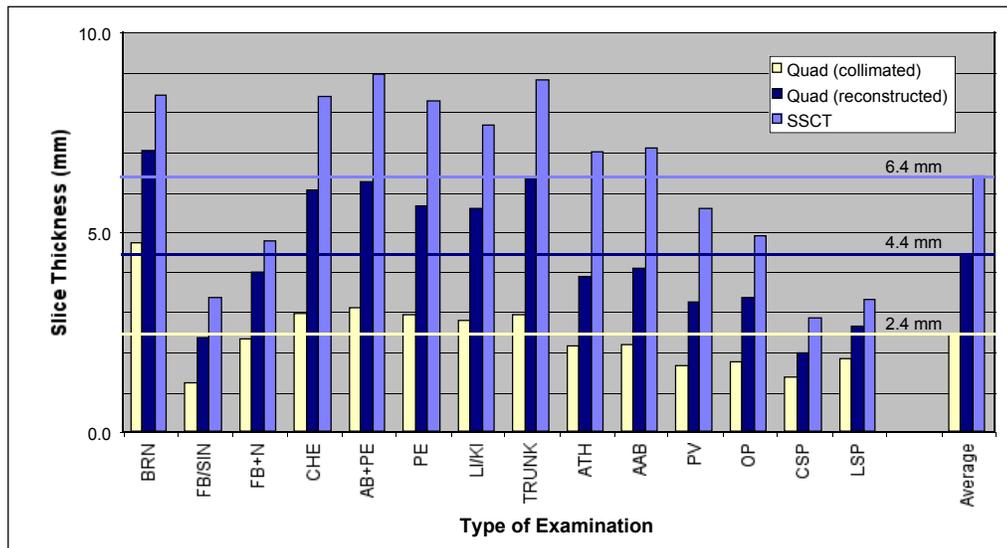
Collimated and reconstructed slice thickness for SSCT and quad slice MSCT scanners. Both collimated and reconstructed slice thickness used with quad scanners (2.4 and 4.4 mm, respectively) is much lower compared to SSCT practice (6.4 mm, collimated = reconstructed) on average (types of examination: BRN = routine brain, FB/SIN = facial bone/sinuses, FB+N = facial bone + neck, CHE = routine chest, AB+PE = routine abdomen (total), PE = routine pelvis, LI/KI = liver/ kidneys, TRUNK = whole trunk, ATH = CTA thoracic aorta, AAB = CTA abdominal aorta, PV = CTA pulmonary vessels, OP = osseous pelvis, CSP = cervical spine, LSP = lumbar spine).
